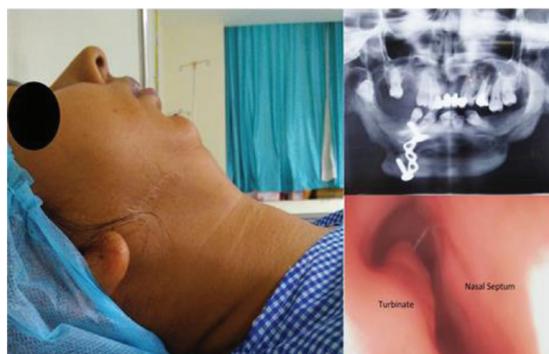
External anatomical deformity, X-ray showing genioplasty, receding mandible, and scopy snapshot showing nearly blocked left nostril
